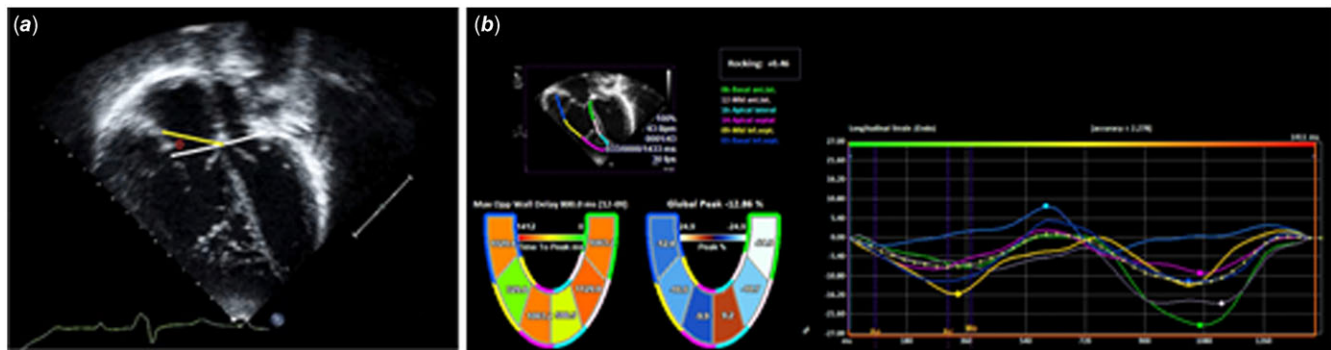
A. apical four chamber view of a study patient with the right ventricular annular tilt technique described in Punn, et al. a line is drawn through the mitral valve hinge points (white), a second line is drawn from the tricuspid valve free wall hinge point to the interventricular septum (yellow). the bisecting angle (θ), is the right ventricular annular tilt. Figure 1B. apical four chamber view of a study patient with right ventricular global strain tracing on the Siemens velocity vector imaging version 3.0.1.15 deformation analysis software (Siemens medical solutions USA).
